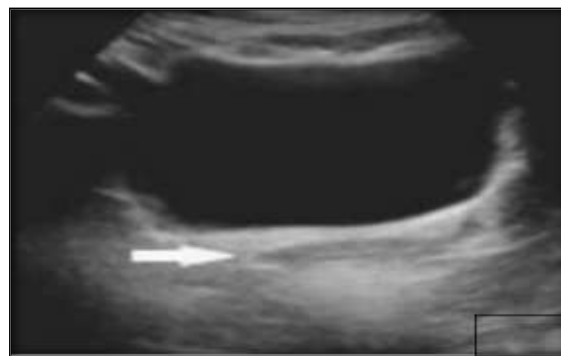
Transabdominal ultrasonography images of the same patient which shows normal ovaries and presences of inferior third of vagina. The image shows absence of the uterus.
